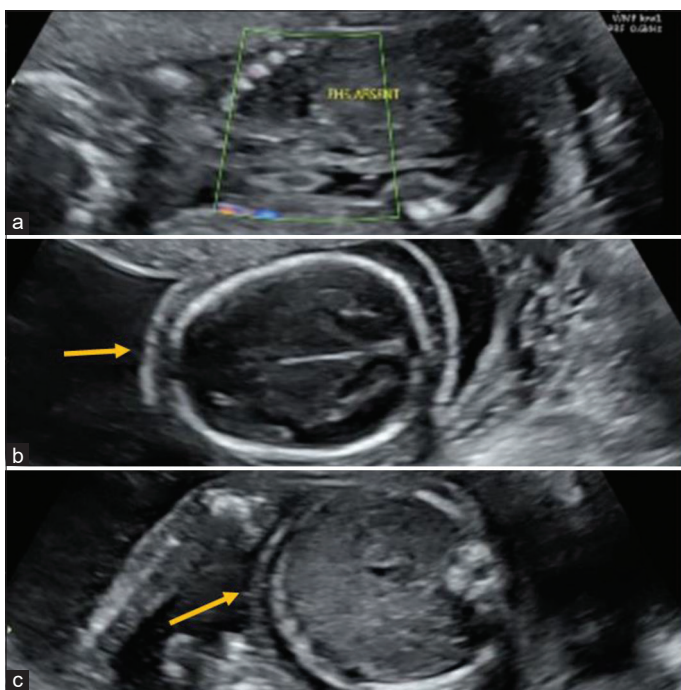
Images of second-trimester scan (18–19 weeks). Ultrasound and color Doppler. Arrows showing absent fetal cardiac activity, scalp edema, and abdominal wall edema – intrauterine fetal demise
